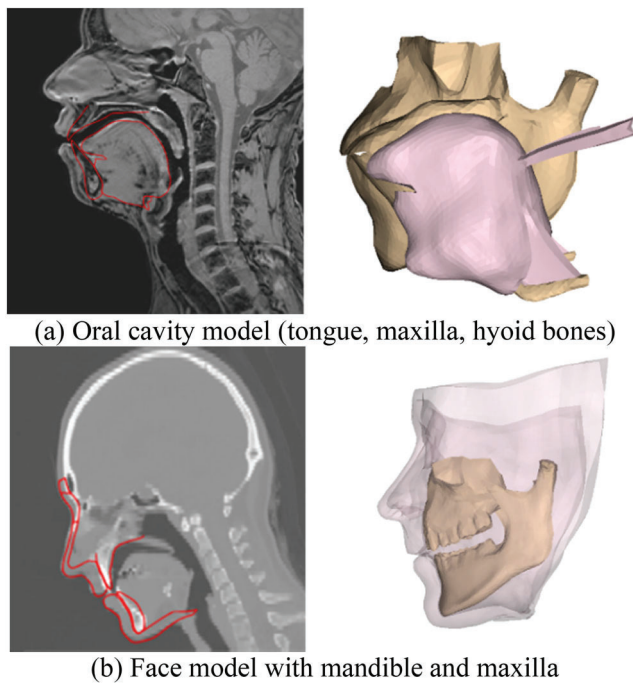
Generated patient-specific FE model. Left: Patient-specific mesh superimposed on MRI data; right: patient-specific FE model.
